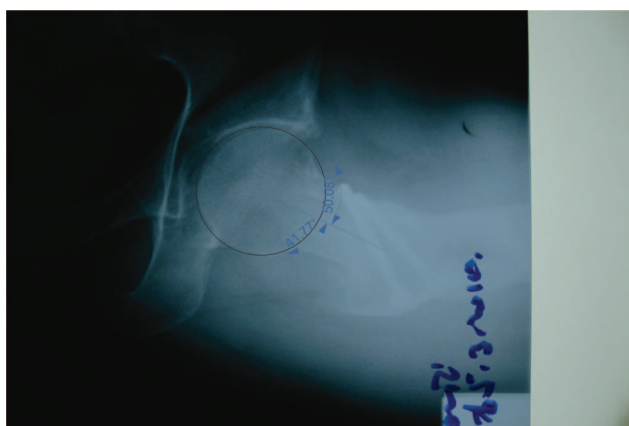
Postoperative Dunn-Rippstein-Müller radiographic image of the hip.
